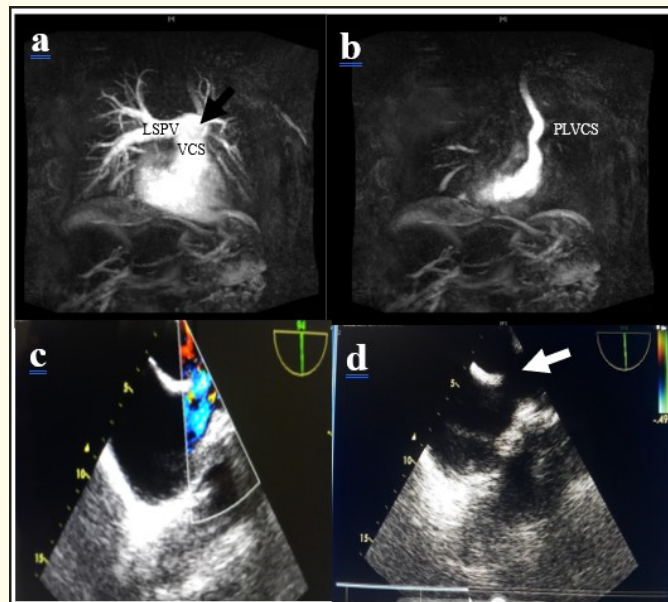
a: Preoperative cardiac magnetic resonance image. b: Preoperative transesophageal echocardiography image.
